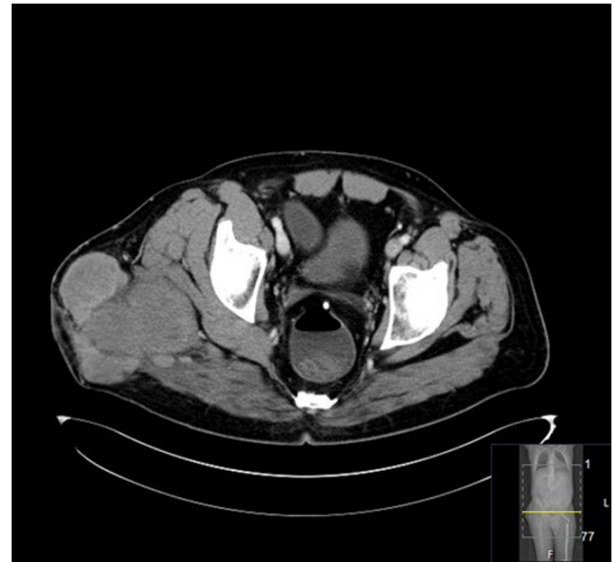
CT axial view of the tumor (2012). CT, computed tomography.
